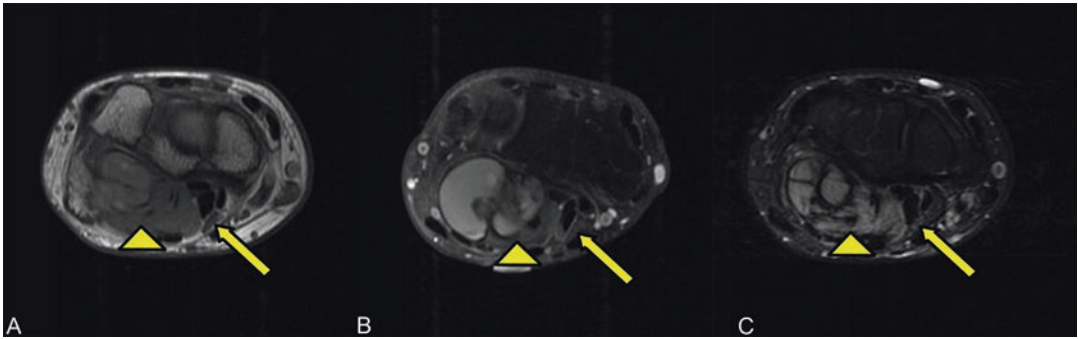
Axial MRI T1 (a), T2 fat saturation (b), and T1 fat saturation post IV contrast (c)—synovial sarcoma within the carpal tunnel; T2 hyperintense, enhancing mass (*arrowhead*) that is displacing and flattening the median nerve (*yellow arrow*)
